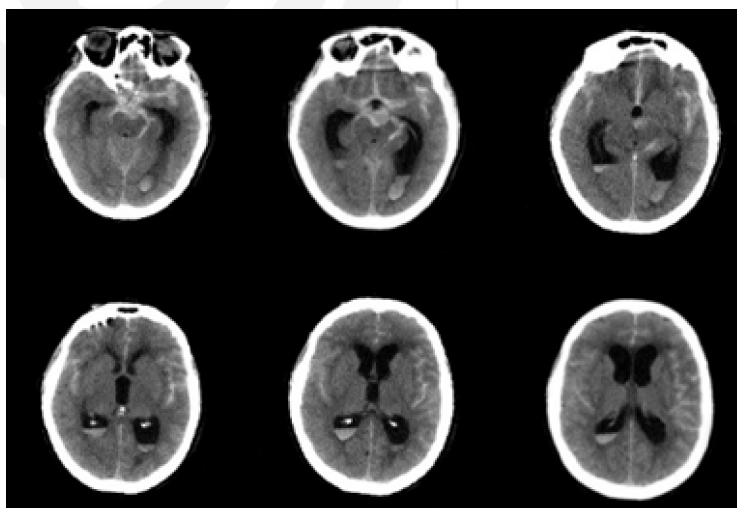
CT scan of brain
